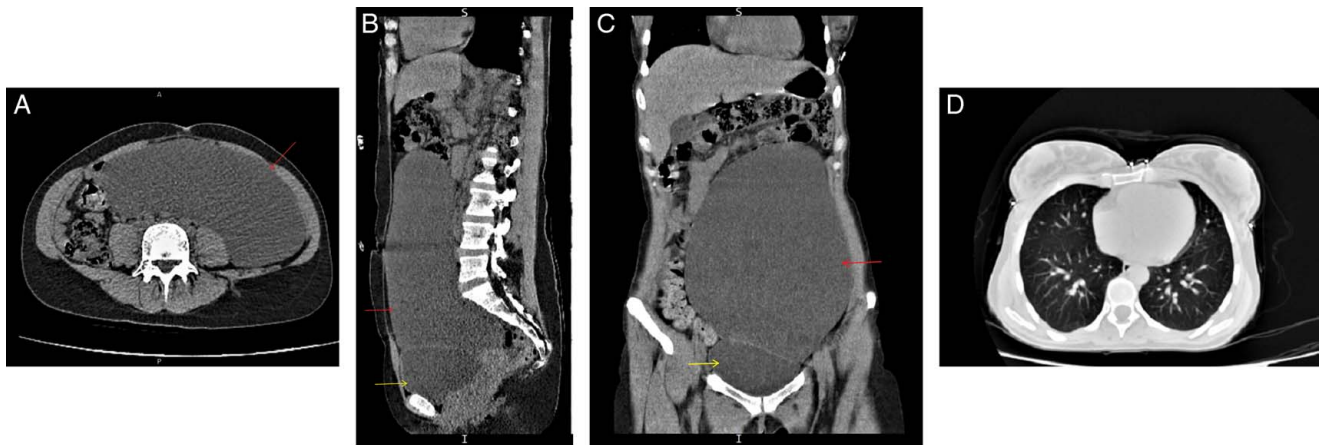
(A–C) Respectively, preoperative axial, sagittal, and coronal views of the Multi-Slice Computed Tomography (MSCT) scan of the chest, abdomen, and pelvis. The photos demonstrate a large-sized solitary well-demarcated uniloculated cystic formation that measures approximately (22 × 19 × 13.5 cm). The cystic content appears to be hypodense with an approximal density of 11 Hounsfield Unit. This cystic lesion occupies most of the abdominal space and is displacing the bowel loops in the left hypochondriac region toward the midline. It is also closely situated to the left psoas muscle and left iliac vessels. It is even compressing the nearby structures resulting in the displacement of the bladder inferiorly and anteriorly. The red arrow in the photos identifies the retroperitoneal cystic formation, whereas the Yellow Arrow identifies the bladder. (D): Preoperative axial view of the MSCT scan of the chest showing a clear lung field with no presence of metastasis from the abdominal cystic formation.
